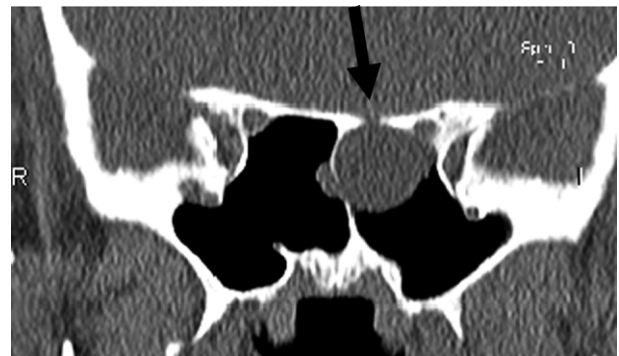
Coronal CT scan section, with demonstration of a narrow lacuna (arrow) at the roof of the sphenoid sinus, with associated round-shaped material in the cavity.
